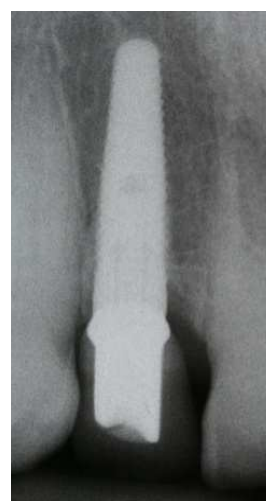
X-ray of the permanent restoration after a follow-up period of 1 year.
